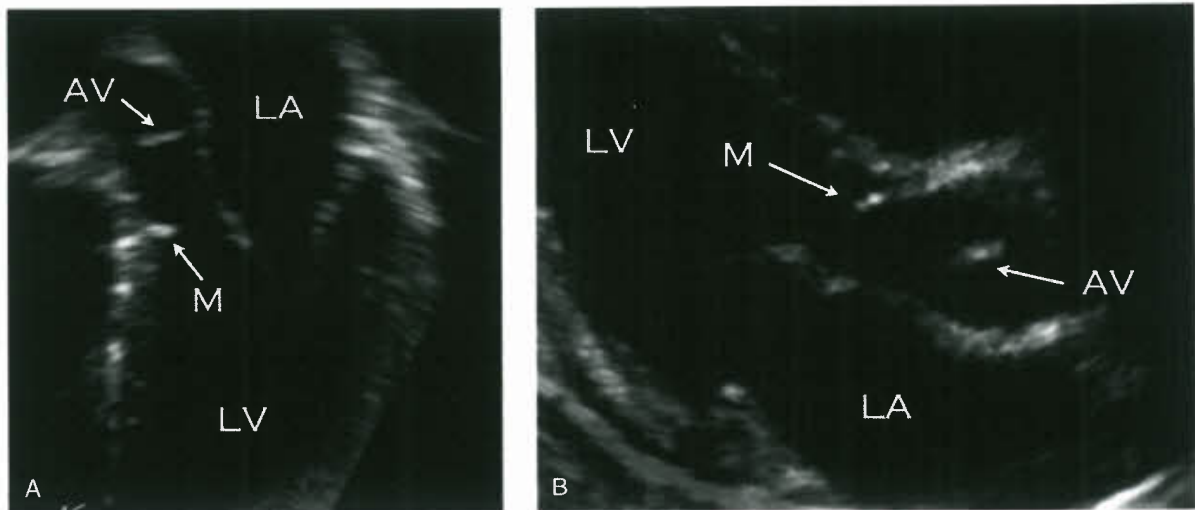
Echocardiographic images of discrete membranous subaortic stenosis. A: Apical five-chamber view. B: Parasternal long-axis view. (M, subaortic membrane; LA, left atrium; LV, left ventricle; AV, aortic valve.)
